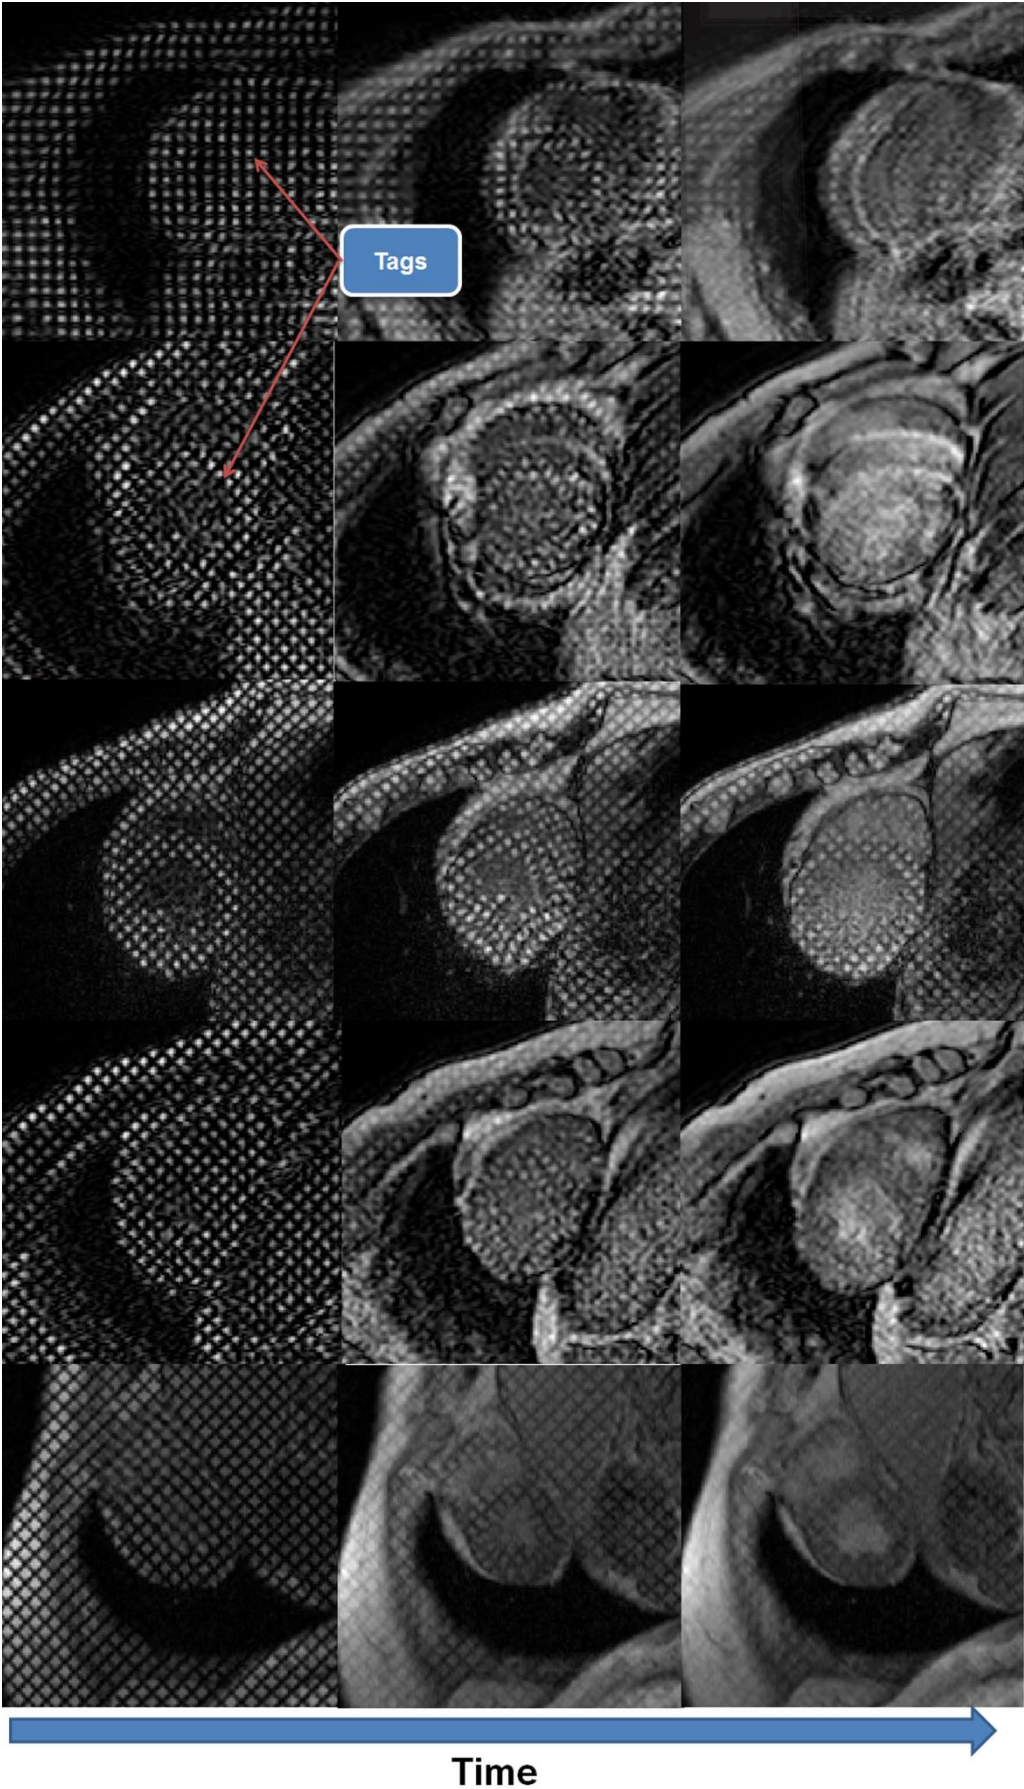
Five t-MRI sequences.
